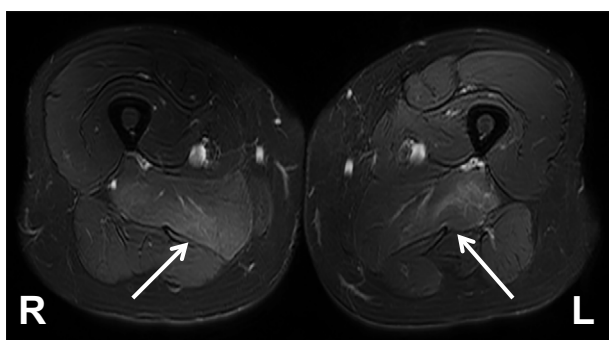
Muscle MRI. MRI with T2-weighted fat-suppressed short-TI inversion recovery sequencing showing mild hyperintense lesions on both sides of the adductor muscles (white arrows).
